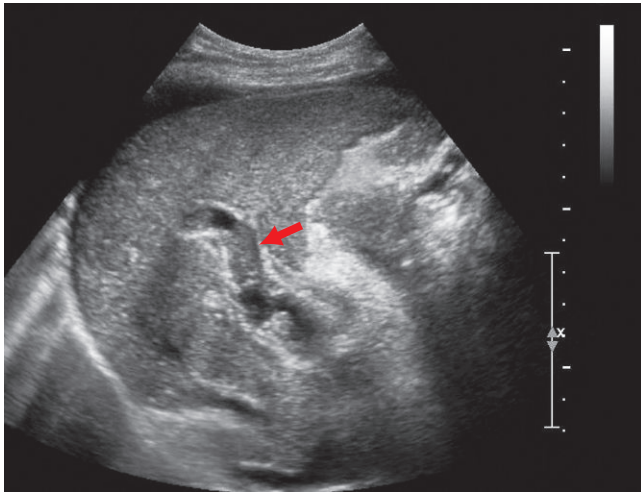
The gray scale sonographic image of the liver shows non-occlusive isoechoic thrombus in the main and right portal vein (arrow).
